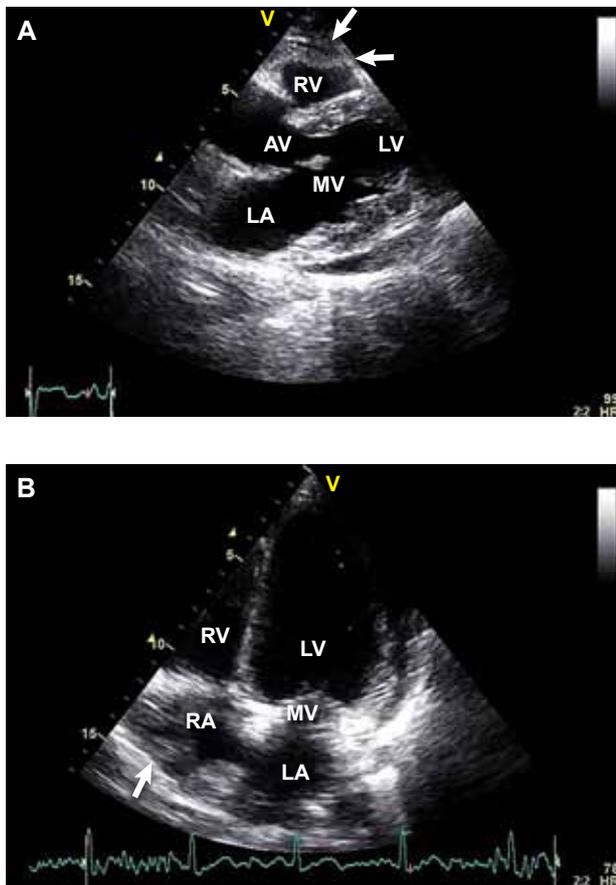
Echocardiographic images (A, parasternal long-axis view and B, 4-chamber view) showing mild to moderate pericardial effusion. Note the diastolic collapse of the free wall of the RV (A, parasternal view, arrows) and the paradoxical movement of the right atrial free wall (B, 4-chamber view, arrow). RV – right ventricle; LV – left ventricle; LA – left atrium; RA – right atrium; MV – mitral valve; AV – aortic valve. From reference 78. © 2010 Clinical and Experimental Rheumatology S.A.S. Reprinted with permission from Clinical and Experimental Rheumatology.
